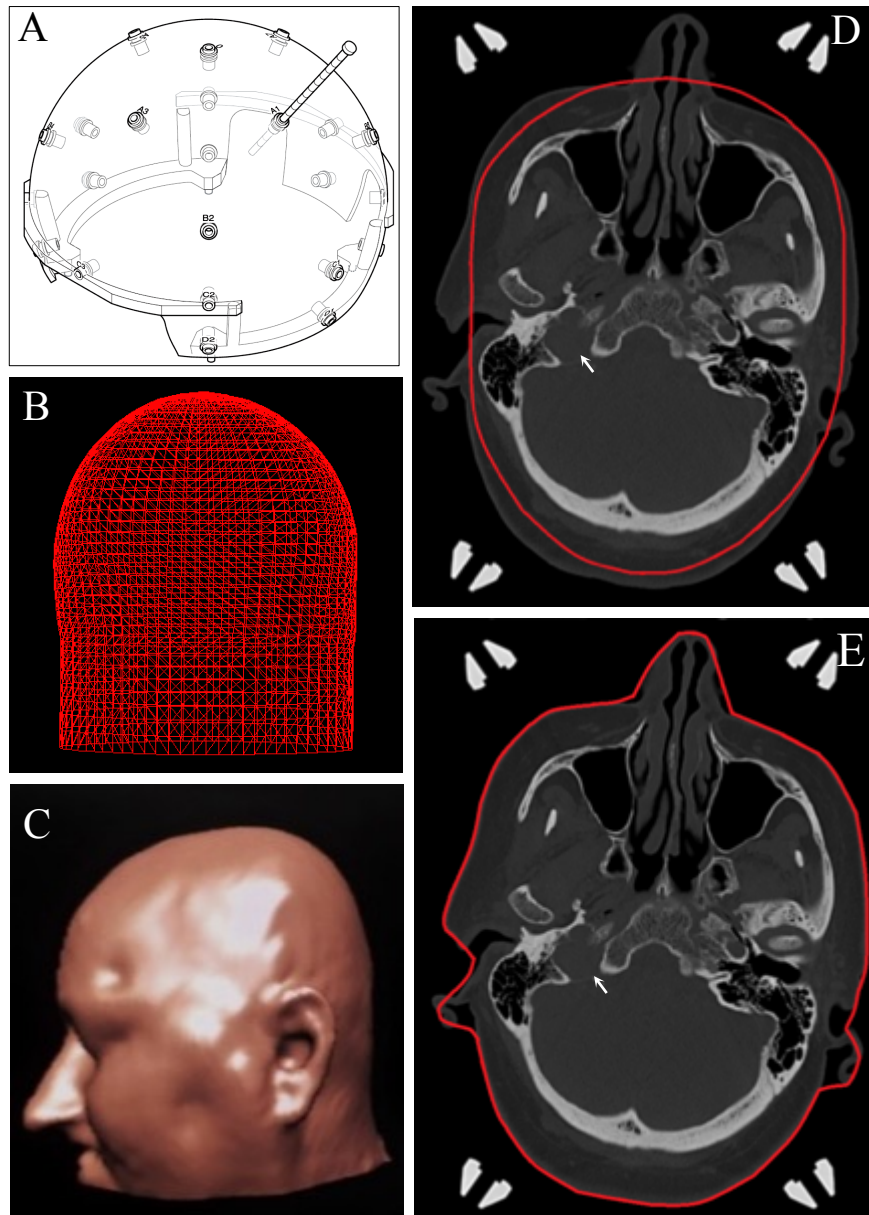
Head shape approximation methods. Skull scaling instrument (A) and the 3D model (B) generated with twenty-four manual measurements of the patient’s head. Segmentation of the head surface using CT outlining produces a more accurate head shape model (C) and visual assessment of the CT scans can easily reveal discrepancies between the manual method (D) and CT outlining (E) in a subject with a right paraganglioma (arrow).
